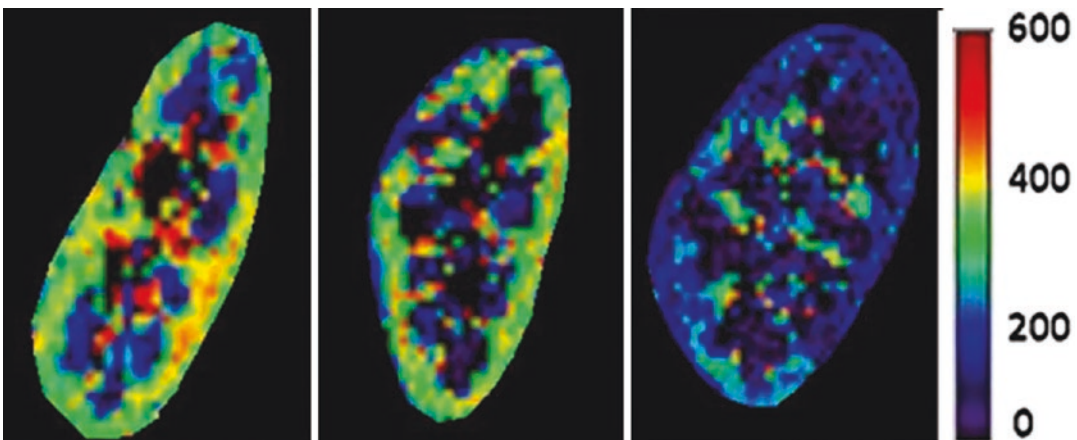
ASL-MRI measured renal blood flow (RBF) maps in a healthy volunteer (left) compared to renal transplant patients with stable allograft function (middle) and impaired allograft function (right). Perfusion values
